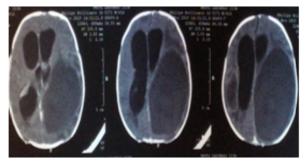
Noncontrast CT scanin 5month old maleshowinglarge abscess in left temporo parietalregion.
